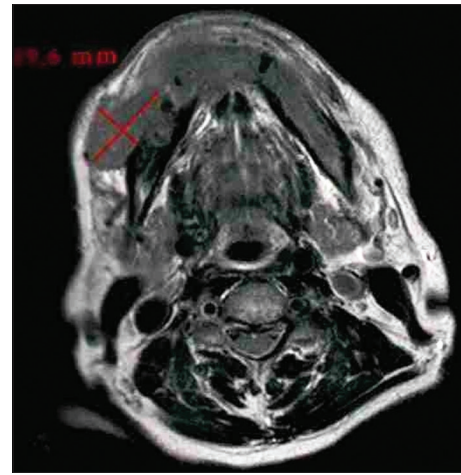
Tumor size on magnetic resonance imaging image (axial view)
